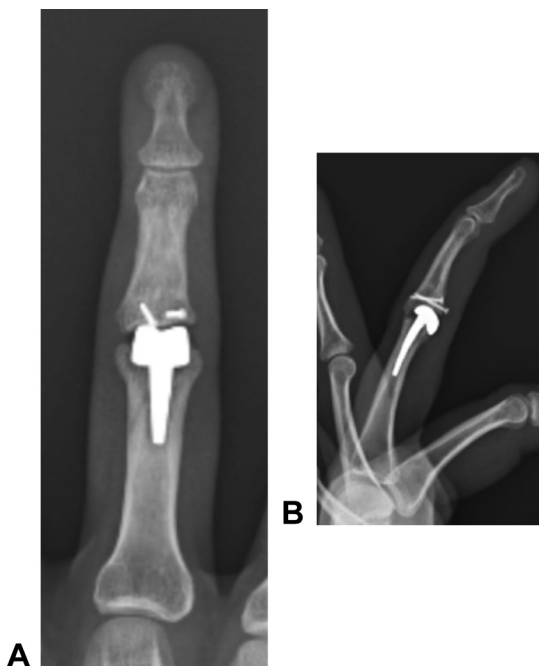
A Posteroanterior and B lateral radiographs 3 years after surgery, after healing of an unrelated P1 base fracture; there is wear at the P2 base hemi-hamate graft site.
